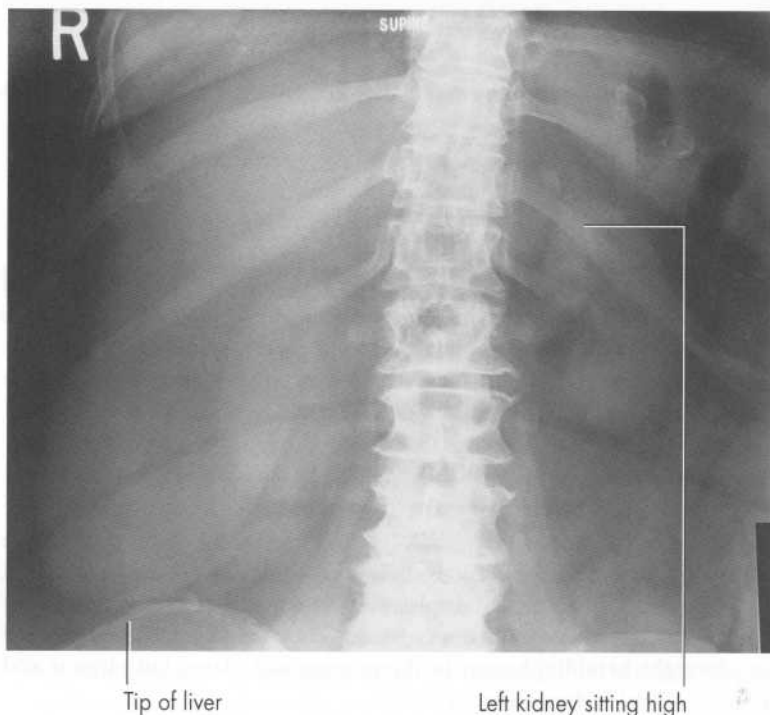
Abdominal radiograph of a 68-year-old woman with a large palpable mass in the R side of the abdomen.
